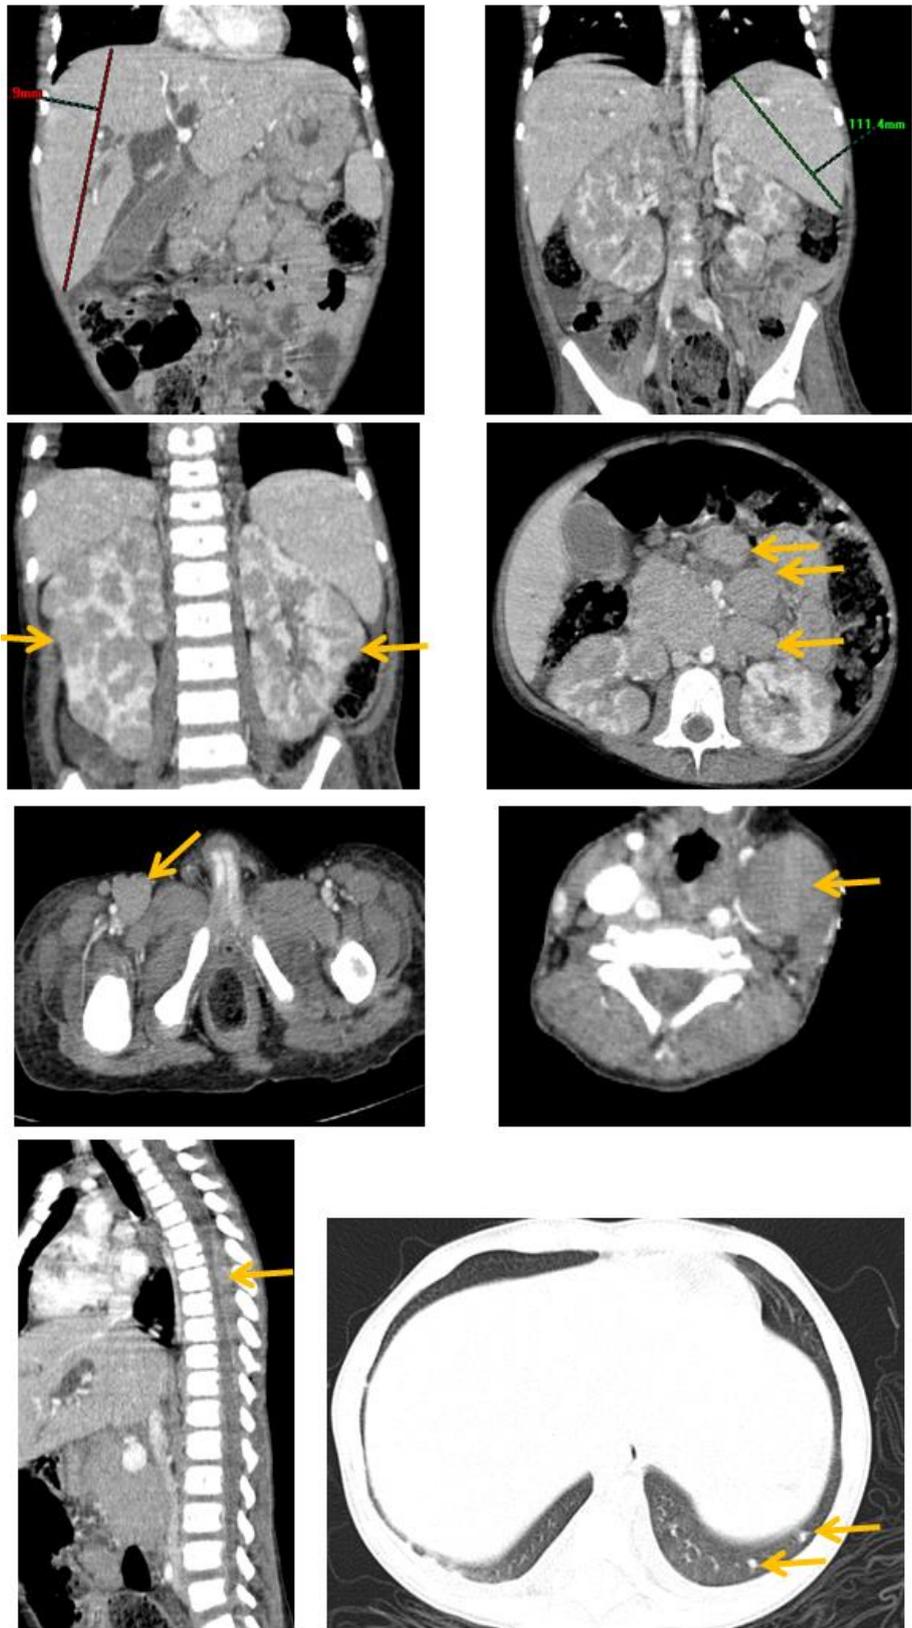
CT scan of the chest, abdomen, and pelvis
